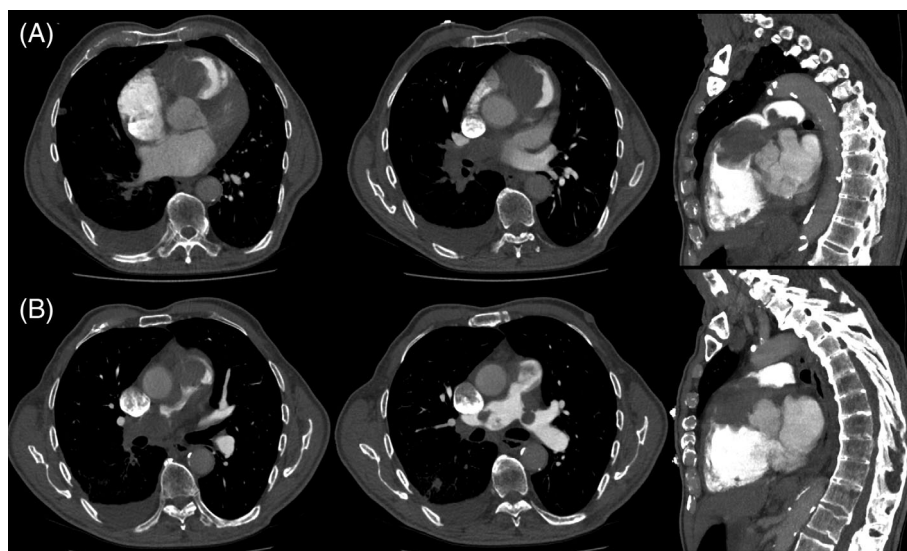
Transverse and sagittal computed tomography pulmonary angiography of Case 1. (A) Images taken at the time of diagnosis showing mass extending from pulmonary trunk into the main pulmonary arteries. Note the anterior and non-dependent position of the mass in the pulmonary trunk. (B) Images taken post-surgical resection showing debulked tumour but large volume of residual disease
